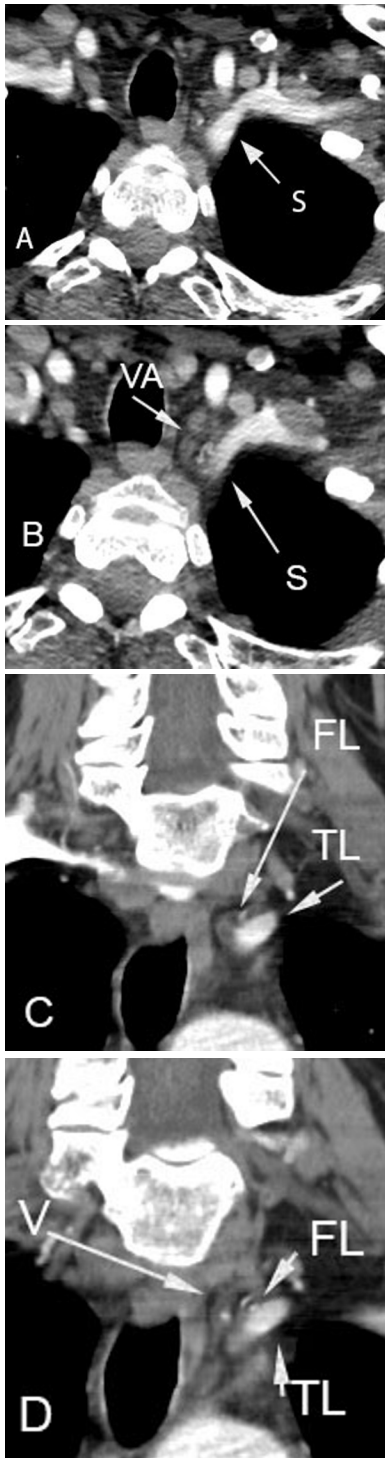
CT angiography. A and B are sequential axial slices that demonstrate a dissection of the subclavian artery (S) at the mid portion, which involves the origin of the vertebral artery (V). C and D are sequential coronal slices; note the normal enhancement of the true lumen (TL), and nonfilling of the false lumen (FL). On B, note the curvilinear hyperdensity in the anterior aspect of the subclavian artery, representing contrast undermining the intimal flap.
